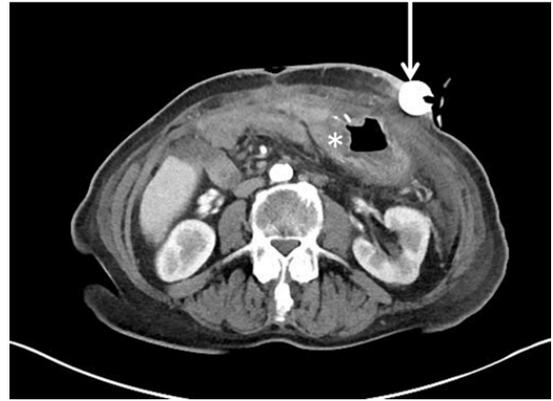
A and B : Buried bumper syndrome A) Axial CT of the abdomen demonstrating a migrated PEG internal bumper (arrow) outside stomach (*) into subcutaneous with associated inflammation along the tract. B) Oblique sagittal reformation demonstrating a migrated PEG internal bumper (arrow) outside stomach (*).
